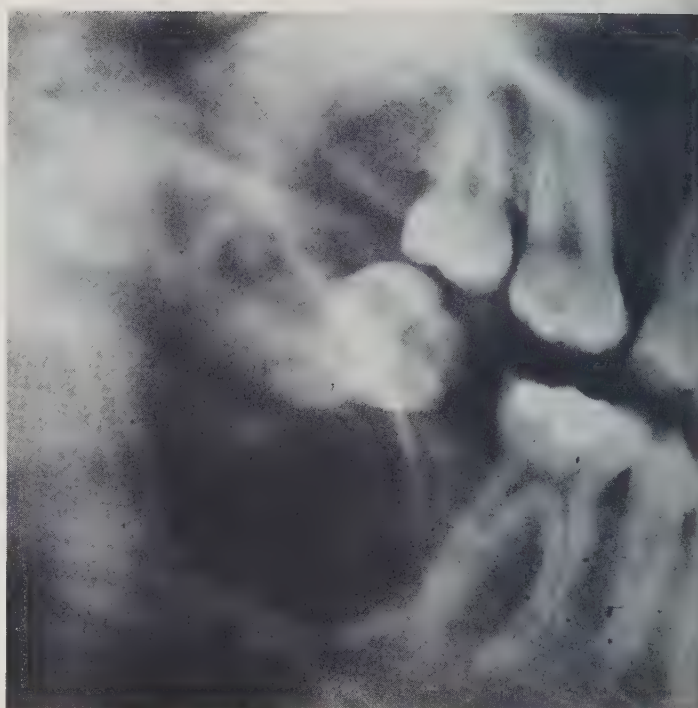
Part of a panorex x-ray of the jaws showing the radiolucency at the right angle of the mandible with its well defined corticated borders. The superior displacement of the roots of the impacted third molar and the inferior displacement of the inferior dental nerve can also be seen.
